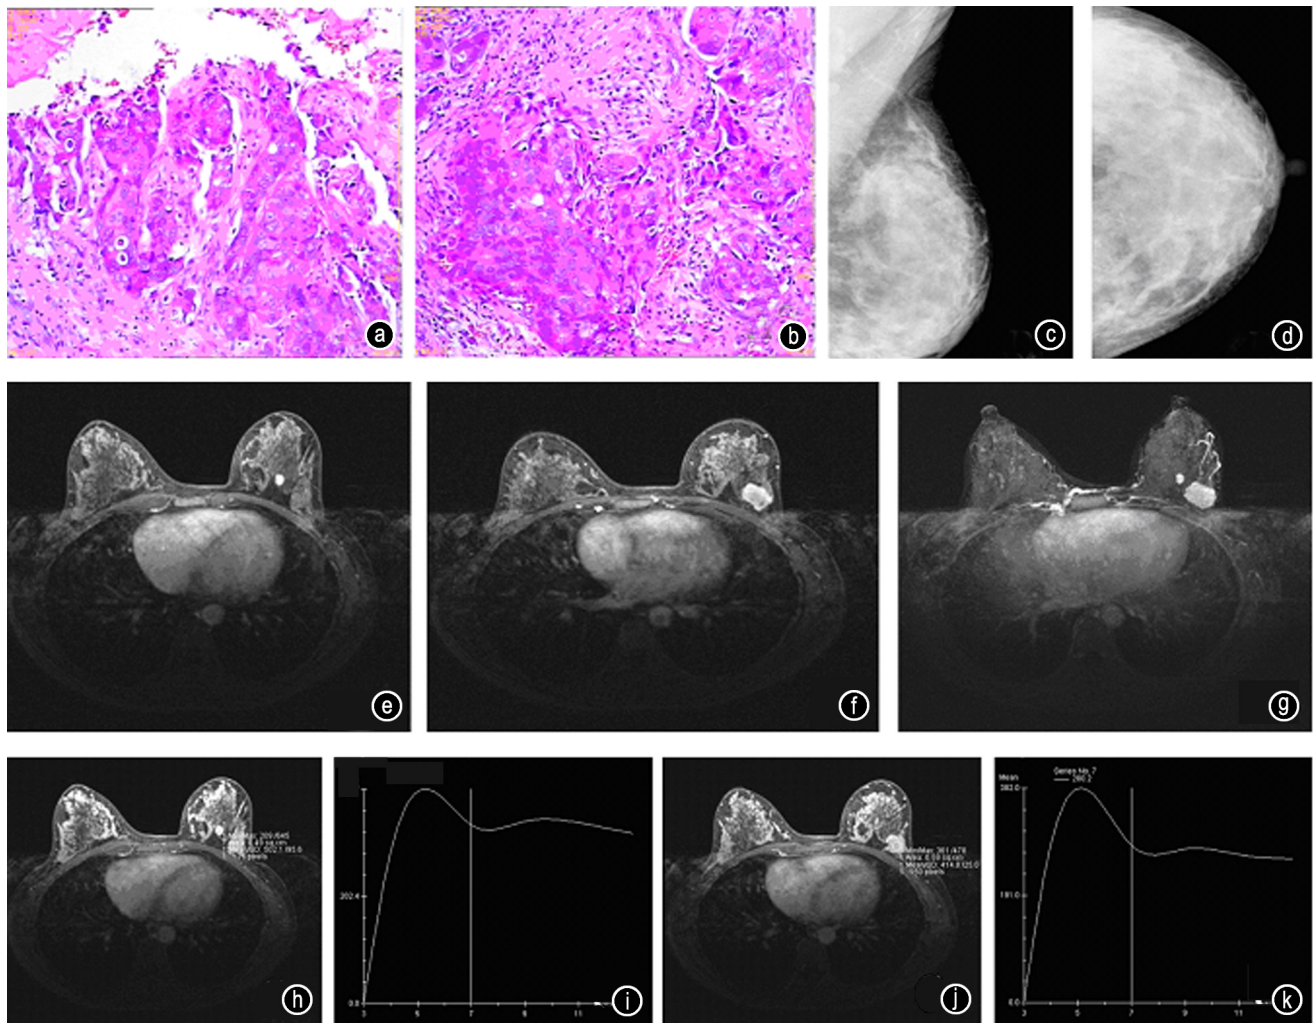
(a and b) left internal mammary invasive ductal carcinoma as confirmed by biopsy; (c) mammography with standard craniocaudal and (d) mammography with mediolateral oblique showed high-density breast glands and suspicious nodules in left internal mammary, (e and f) DCE-MRI showed it was multicentric breast cancer; (g) tumor adjacent vessels thickening and increased in subtracted images; (h–k) the time-signal intensity curve showed fast rise downhill type (type III)
